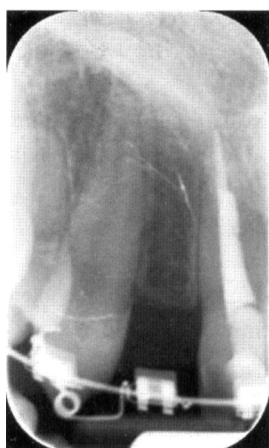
Pre-Operatory Orthopantomography (patient A)
